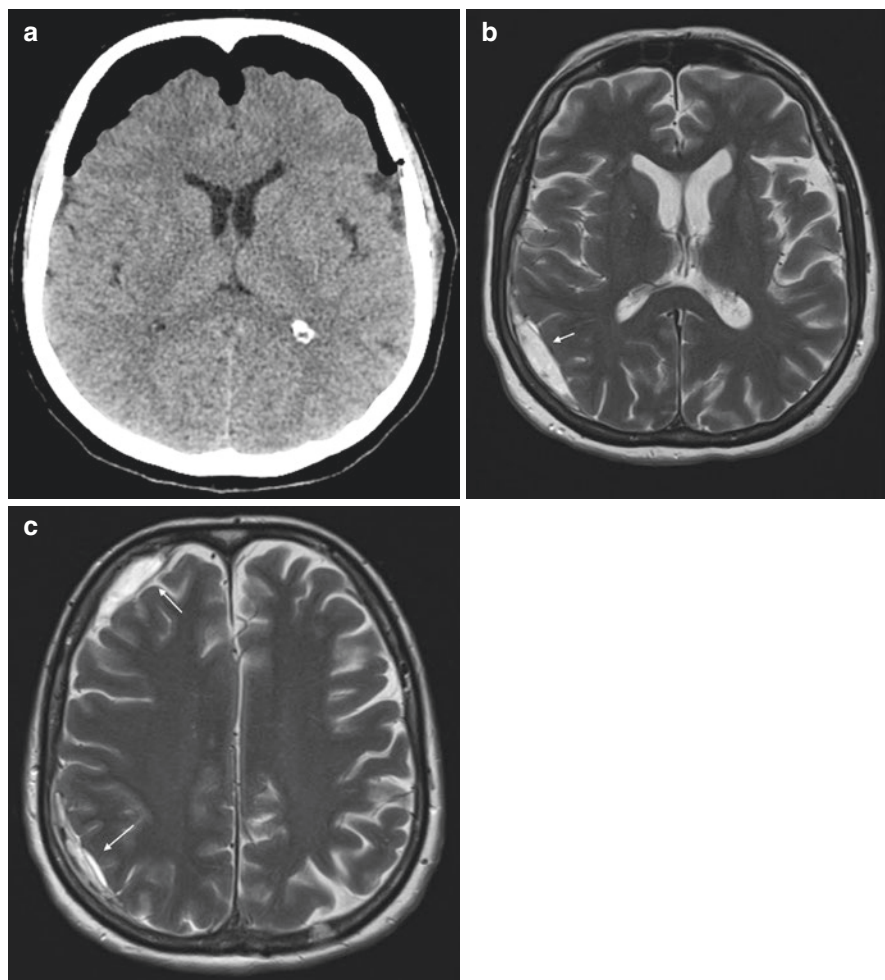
Tension pneumocephalus in a 47-year-old man status after debulking of a meningioma located inside the superior sagittal sinus and subdural hygromas after few months of the craniotomy. Axial CT image (a) shows pneumocephalus along the bifrontal convexities with mass effect on the frontal lobes and displacement of the frontal lobes from the falx cerebri, also known as the “Mount Fuji Sign.” Follow-up axial T2 MRI (b, c) shows subdural hygromas, extra-axial fluid collections with T2 hypersignal, over the right parietal and (c) frontal subdural spaces (arrows)
